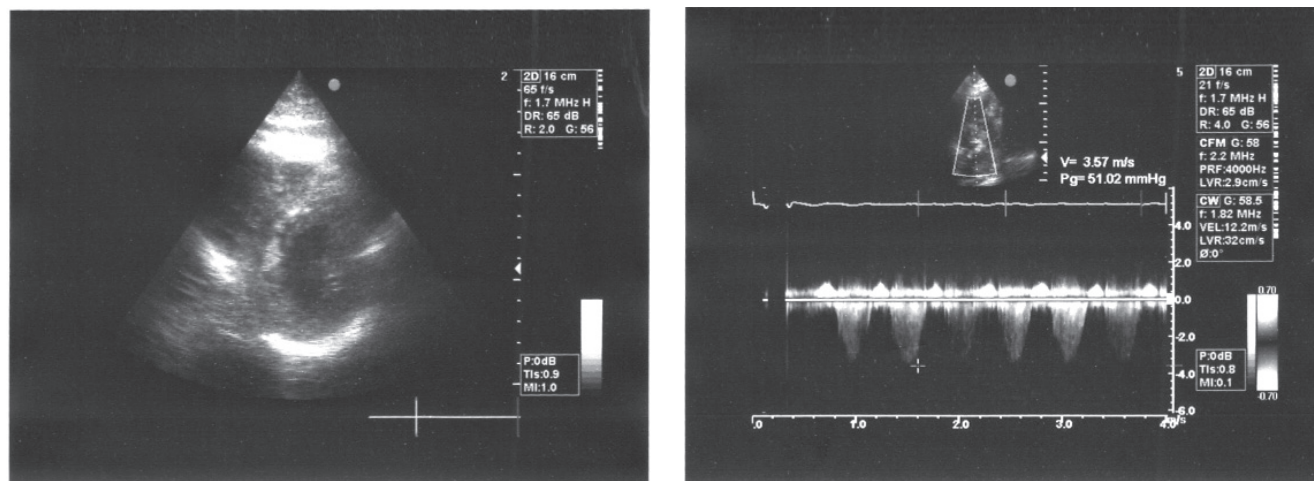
Echocardiographic findings in PE: normal left ventricle and enlarged right ventricle, elevated RVSP (right ventricular systolic pressure).
